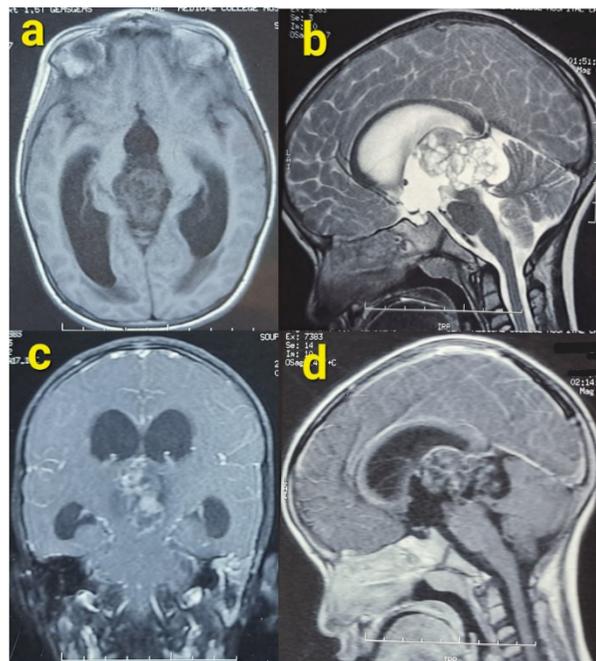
MRI scan of pineal tumor
